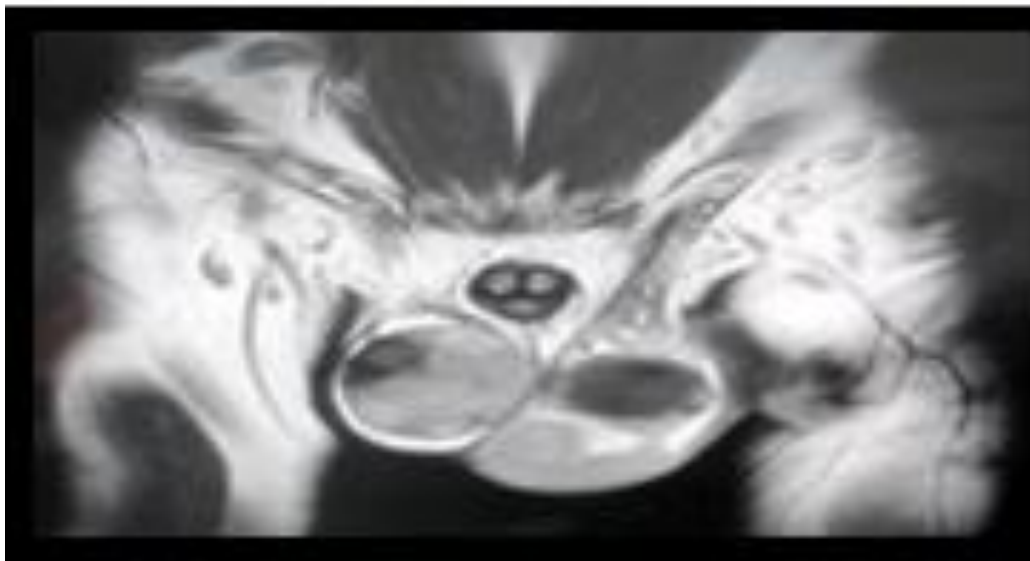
MRI Pelvis showing heterogeneous to hypotense T2W lesion involving b/L testes with moderate diffusion restriction and few of the lesion showing internal haemorrhage
